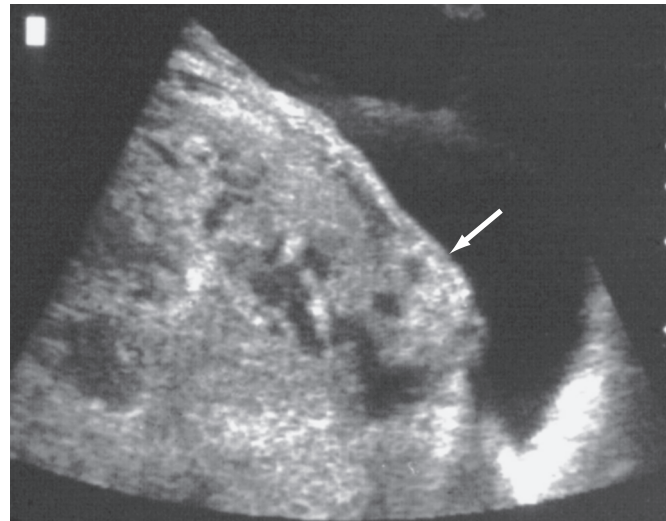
Ultrasonic image of focal placenta accreta (arrow). An area at the uterine-placental interface demonstrates loss of the normal hypoechoic zone, thinning and disruption of the uterine serosa-bladder interface, and a focal exophytic mass within the placenta.
